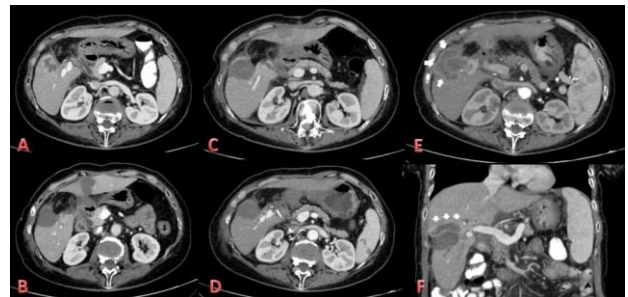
Intravenous contrast enhanced Computed Tomography (CECT) images of a patient with local recurrence of colorectal liver metastasis (A-F). Preprocedural axial CECT image of the metastatic lesion which was showing contrast enhancement peripherally (A). Axial CECT of the metastatic lesion obtained at the following day of ablation showed the ablation zone without any pathologic contrast enhancement (B). Axial CECT images showed no residual tumor and the evidence of any local recurrence on site in postprocedural 1st (C) and the 4th (D) month controls. However a gross local recurrence with a peripheral contrast enhancement (arrows) was demonstrated on axial (E) and coronal (F) CECT images on 7th month control
